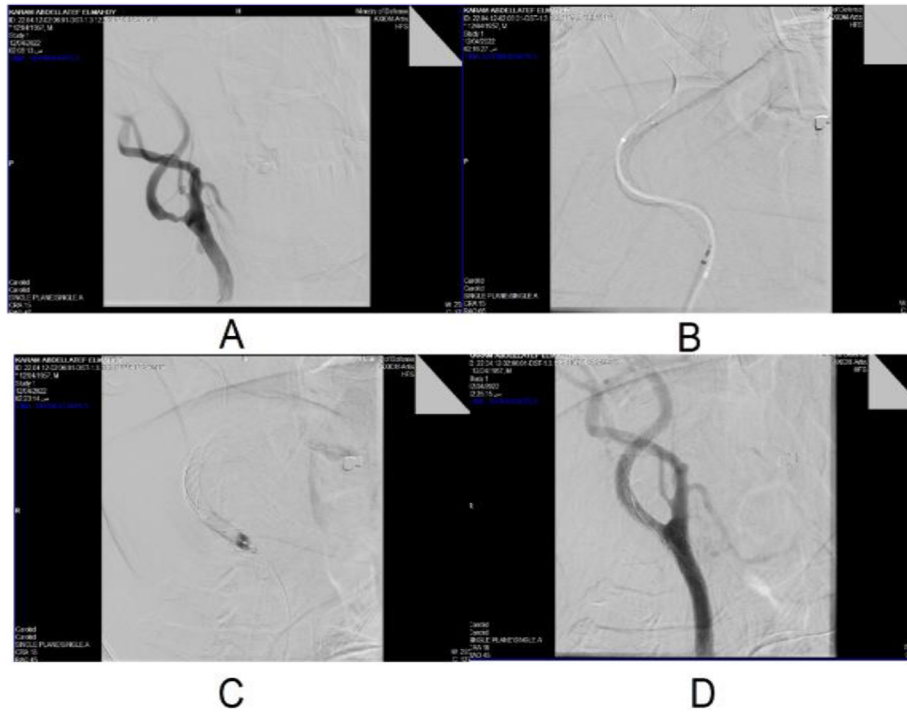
A) Rt ICA DSA, lateral view. Severe atherosclerotic stenosis of the proximal ICA, B) Deployment of Casper stent C) Post-dilaltion using (3.5-6mm in diameter) balloon, D) plain film of the neck oblique projections to document the expansion of the stent.
